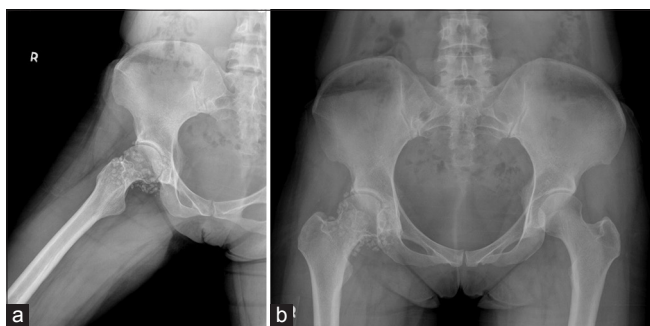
(a and b) Preoperative radiographs showed a lot of calcified loose bodies around right hip
